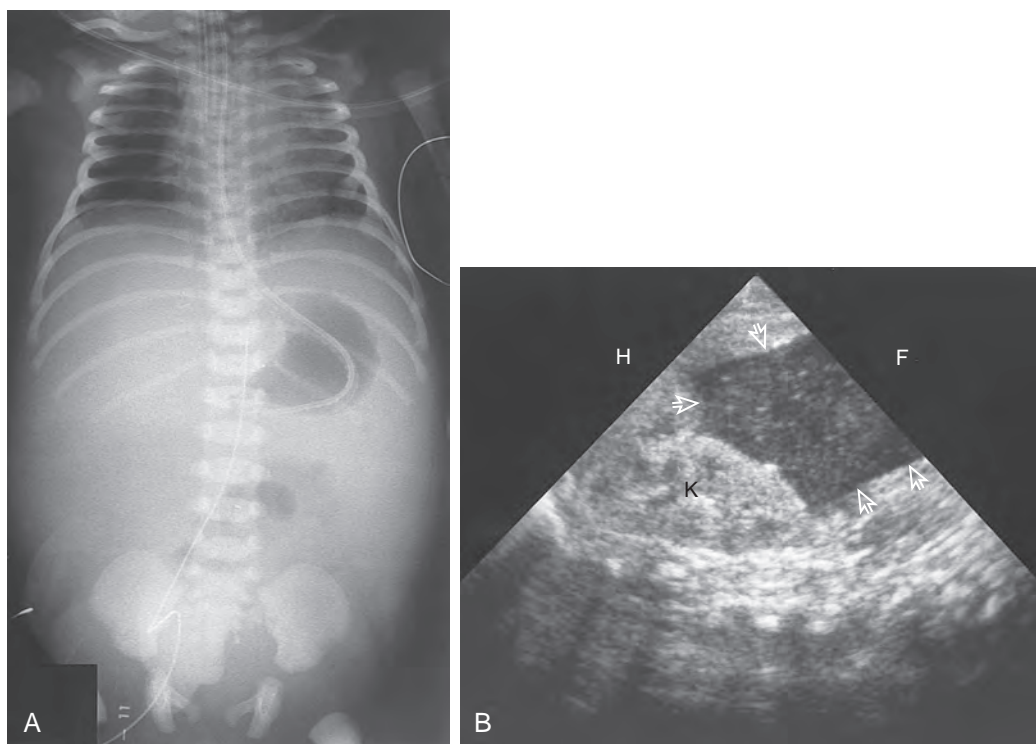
Meconium peritonitis. A. On the chest and abdomen radiograph, there is a paucity of abdominal gas, perhaps because of suction and ventilation through the endotracheal tube. Meconium peritonitis causes generalized abdominal haziness, bulging flanks, and centralization of bowel loops. B. The longitudinal sonogram reveals a peritoneal collection of meconium (arrows) anterior to the echogenic neonatal kidney (K). The meconium is less echogenic than the solid structures, but it contains more echoes than simple transudative ascites. H, Cephalic; F, caudal.
